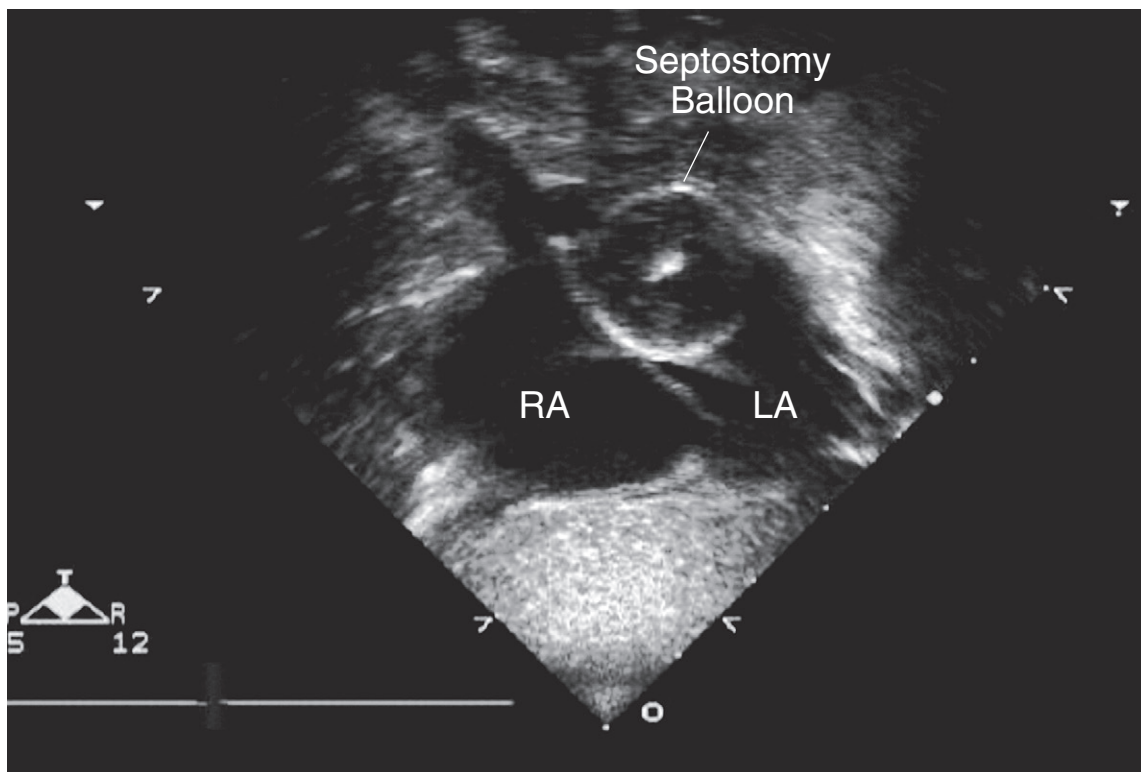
Echocardiography-guided balloon atrial septostomy. From the subcostal view, the septostomy balloon is easily seen as it inflates in the left atrium (LA). RA, Right atrium.
